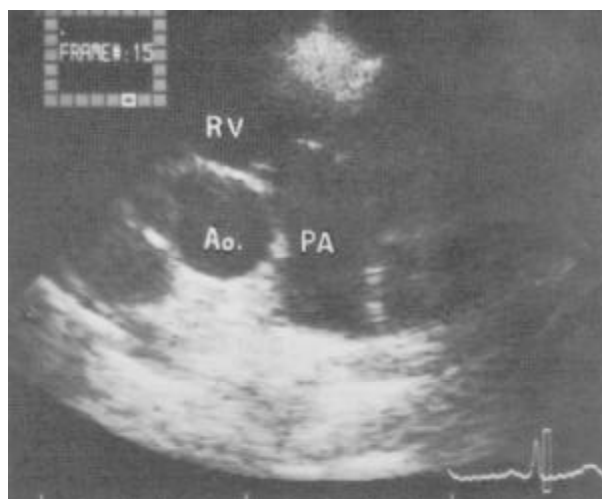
Conventional parasternal short axis image. The end-diastolic displacement of the pulmonary leaflets toward the right ventricular outlet can be observed. Abbreviations as before.
